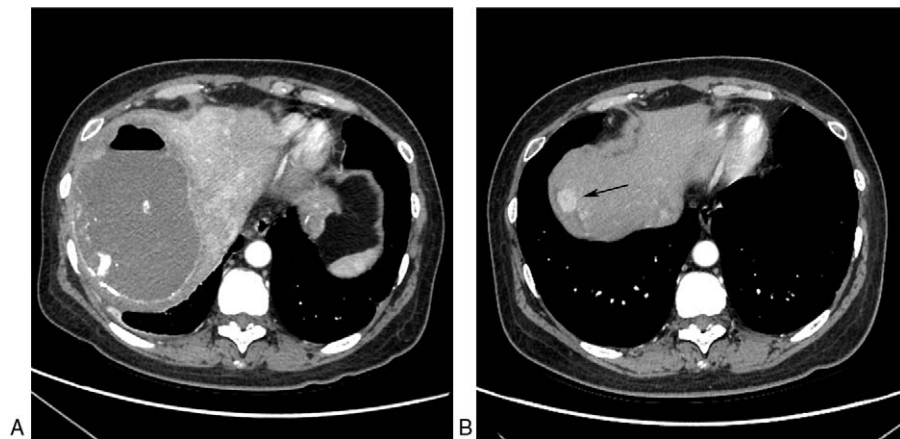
An abscess of 12.2 \times 9.0 cm with air fluid level located in the original mass 2 weeks after embolization (A), repeated CT scan 3 months after drainage (B) revealed few nodular residual lesions in arterial phase (arrow). CT = computed tomography.
